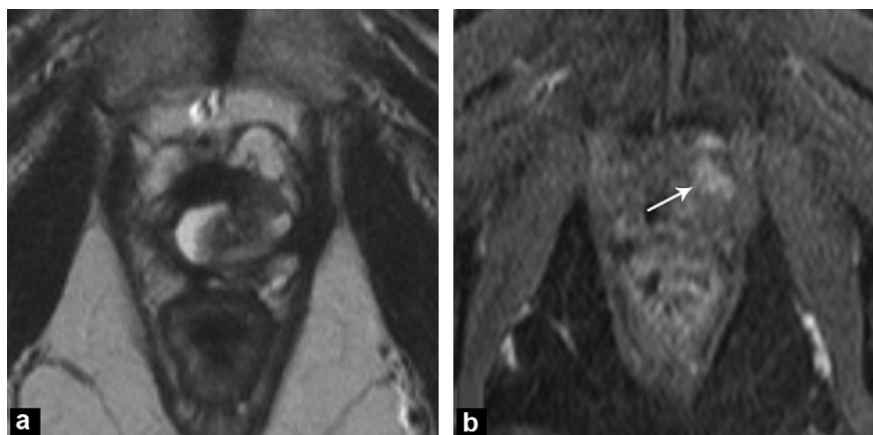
A 75-year-old patient treated with focused ultrasound 2 years previously for a Gleason 6 prostate adenocarcinoma with a PSA of 8.3 ng/mL. The persistence of high PSA concentrations (5 ng/mL) led to discovery in the biopsy of residual cancer of the right mid part treated by a second course of focused ultrasound. Despite this second treatment, the PSA concentration remained at 5 ng/mL: a: T2-weighted axial slice showing no clear anomaly; b: the dynamic axial slice after contrast agent injection shows a left anterior-basal nodule with early enhancement (arrow). Targeted biopsies of the nodule showed a Gleason 6 prostatic adenocarcinoma.
